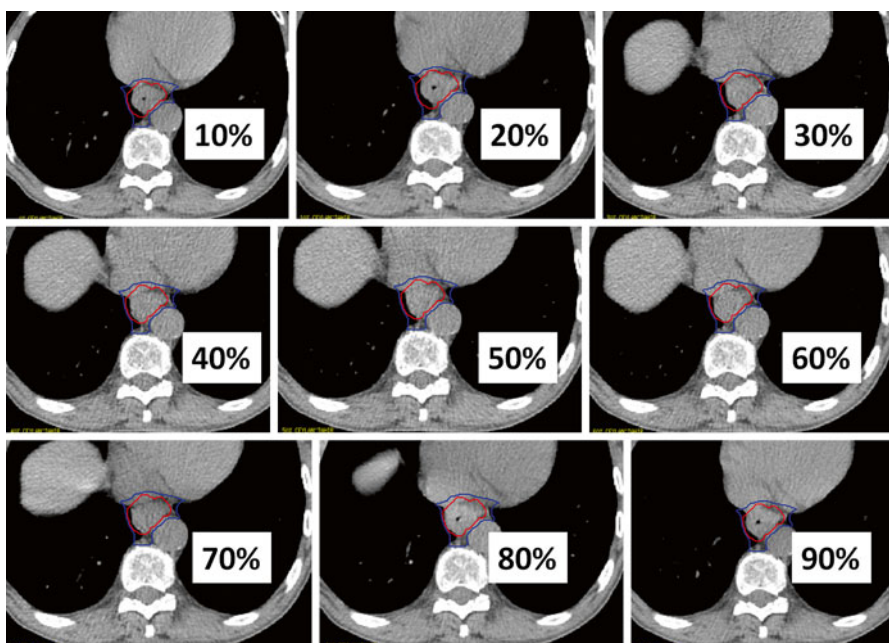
iGTV contouring based on 4D-CT including respiratory data sets “binned” by phase (0–100 % at 10 % intervals); phase delineation at maximum intensity projection (MIP) also generally covers all movement in all phases
